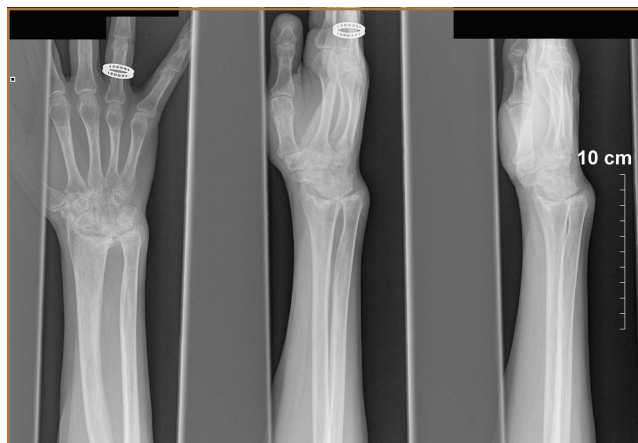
Postoperative radiographs of a patient at 10-year follow-up demonstrating equally weighted 2-bone forearm.
